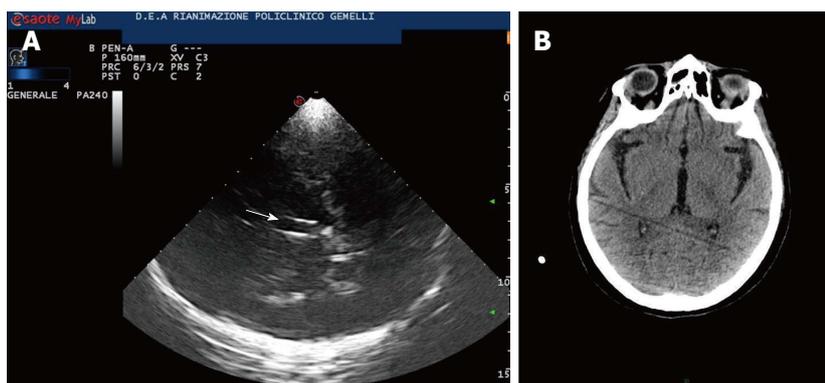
Third ventricle. A: Diencephalic transverse scan. A small enlargement (12 mm) of third ventricle is shown (arrow); B: Third ventricle in computed tomography (CT). CT scan correspondent of Figure 3A is shown.
